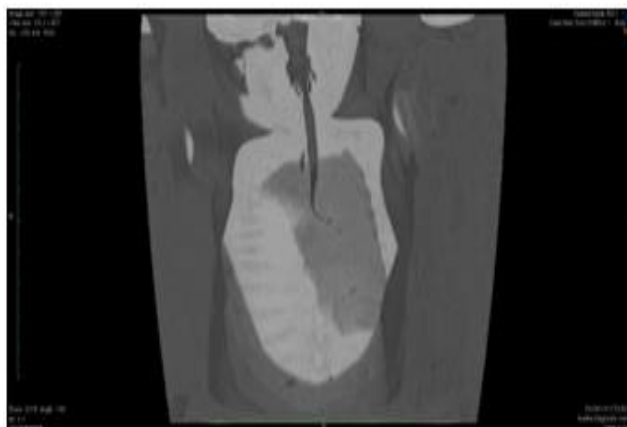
CT Virtual bronchoscopy images shows trachea as continuing the left main bronchus with aplasia of right main bronchus which is almost diagnostic of the condition
